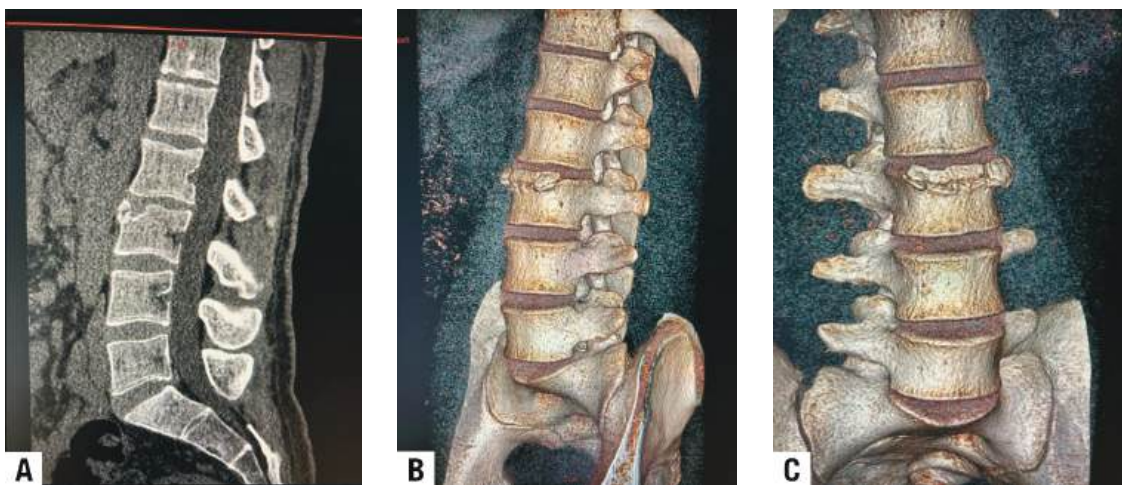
CT scan showed a cortical marginal irregularity of the L3 apophyseal plates with mild depression with an avulsion-triangular bony focus anteriorly with sclerotic edges compatible with a limbus vertebra (A), 3D volume rendering imaging (B,C).
